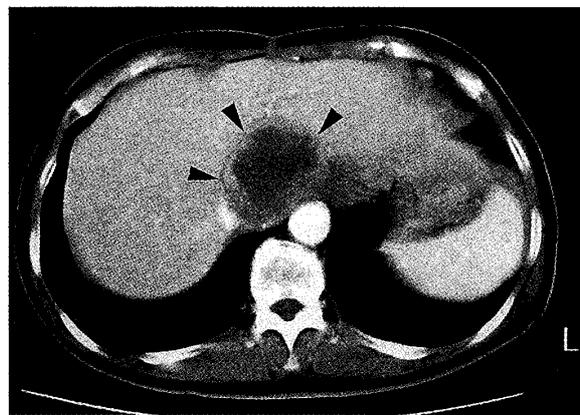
An abdominal CT showed disseminated tumor near the caudate lobe
